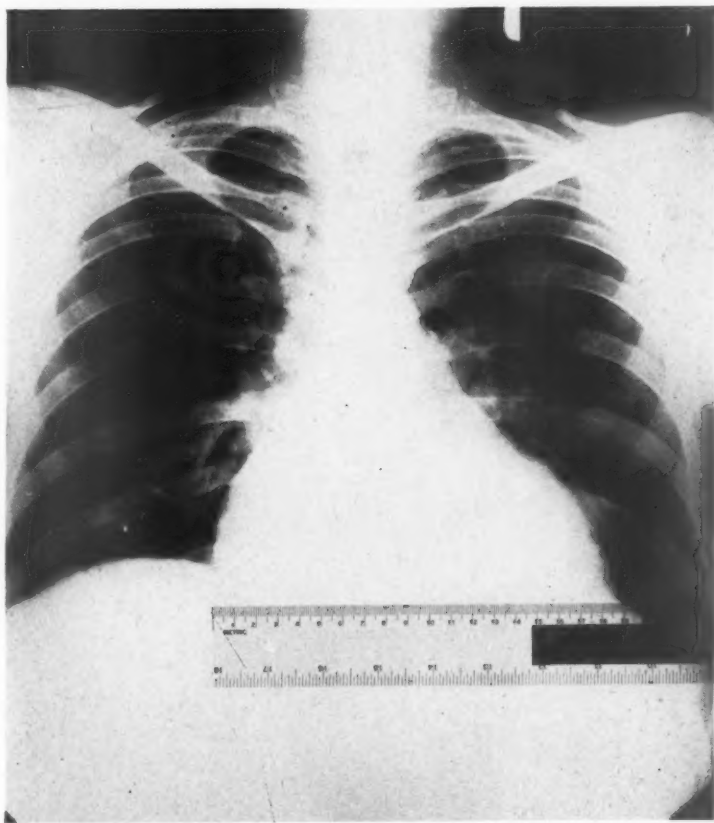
Roentgenogram of the heart before treatment.
